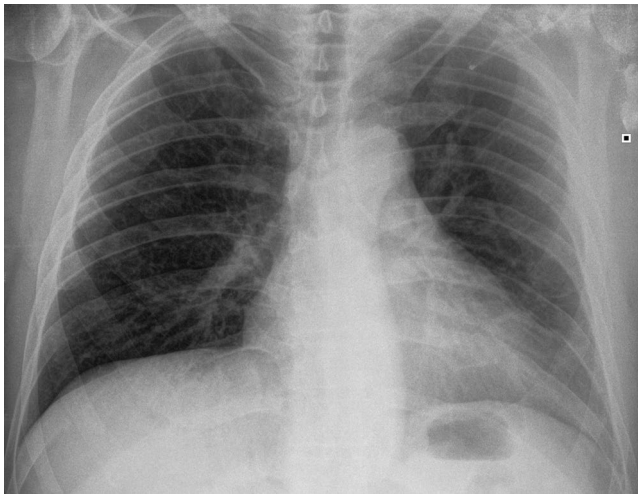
Patient's chest X-ray upon admission
